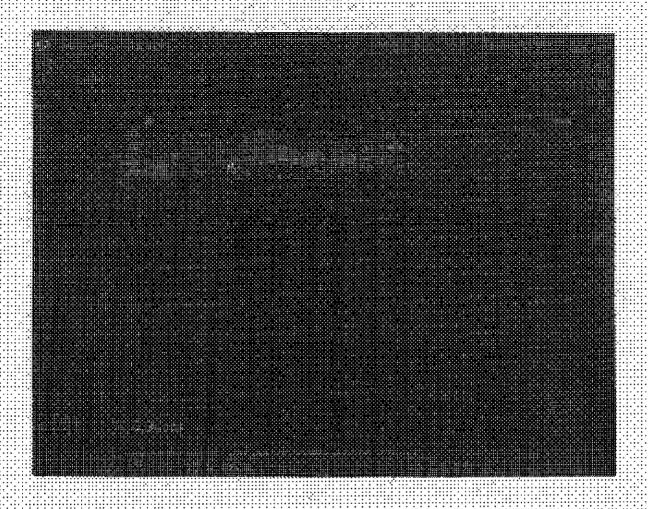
Images of metacarpo-phalangeal joints dorsal and palmar demonstrate no cortical irregularity or distraction. Synovial fluid and/or hypertrophy are not noted on the joint margins. Doppler signal to dental by synovial hypertrophy was not seen. No A1 pulley hypertrophy or abnormality as seen with trigger finger.
